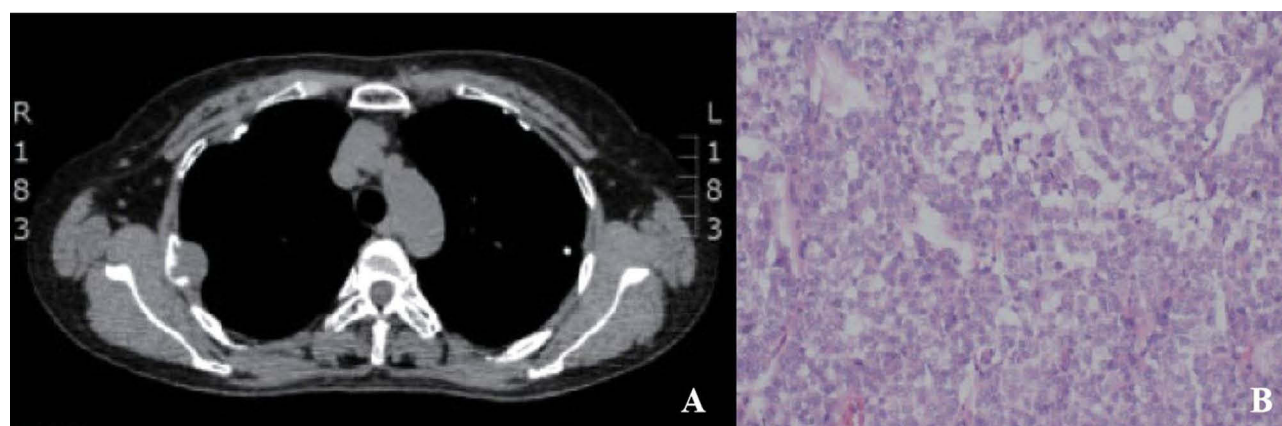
CT Imaging of Rib Metastasis. (A) Chest CT cross-section showing destruction of the fourth rib with a soft tissue shadow, indicating metastatic malignancy. (B) Pathological section confirming rib invasion by cancer cells. These images underscore the extent of metastasis, necessitating vigilant symptom management through personalized nursing interventions.
